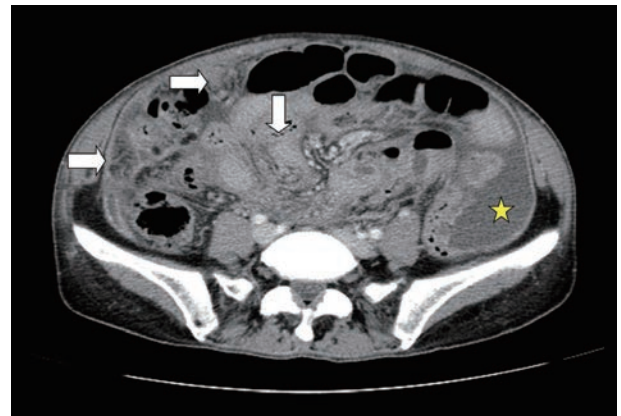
Post-contrast medium-enhanced computed tomographic image, exhibiting diffuse enhancement and thickening of the peritoneum with ascites (star) and multiple peritoneal nodules (arrows), which were suggestive of peritoneal carcinomatosis.
